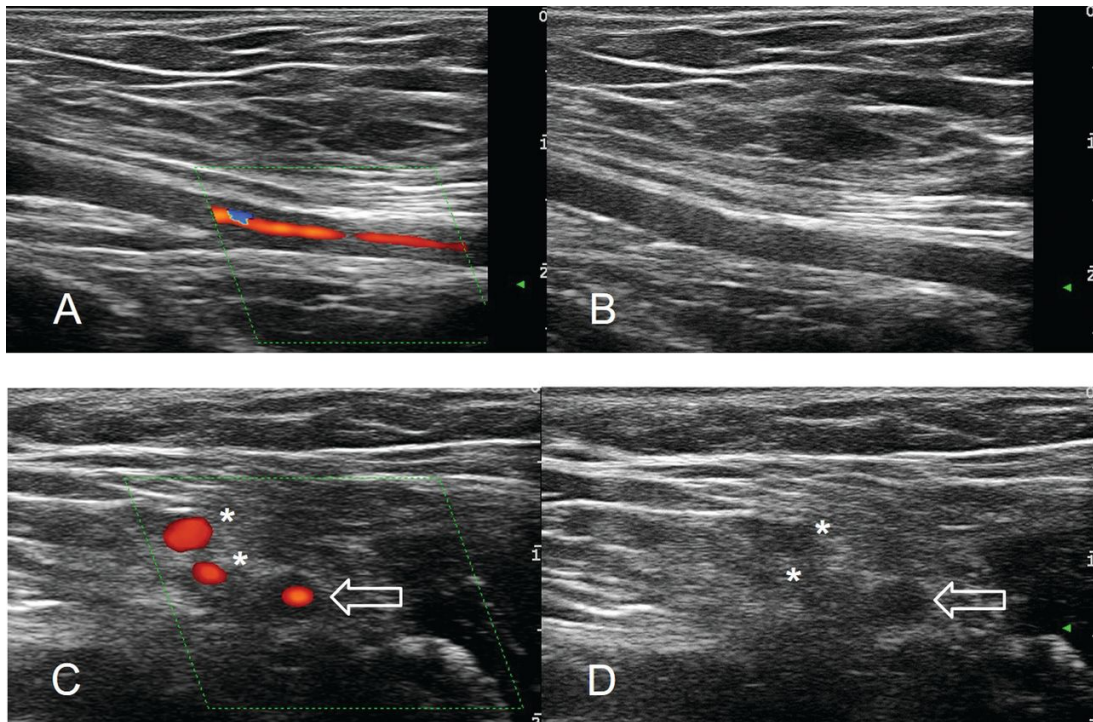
Halo sign of an axillary artery of a patient with GCA in the full exercise in longitudinal (A, B) and transverse (C, D) views. It is only visible when applying colour Doppler (A, C). In the transverse views, collateral vessels without halo sign (*) appear larger than the lumen of the affected axillary (arrows). GCA: giant cell arteritis.
